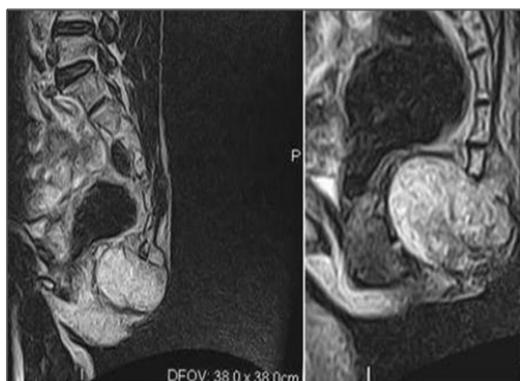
Multilobulated mass in the sacrococcygeal region on magnetic resonance imaging.
